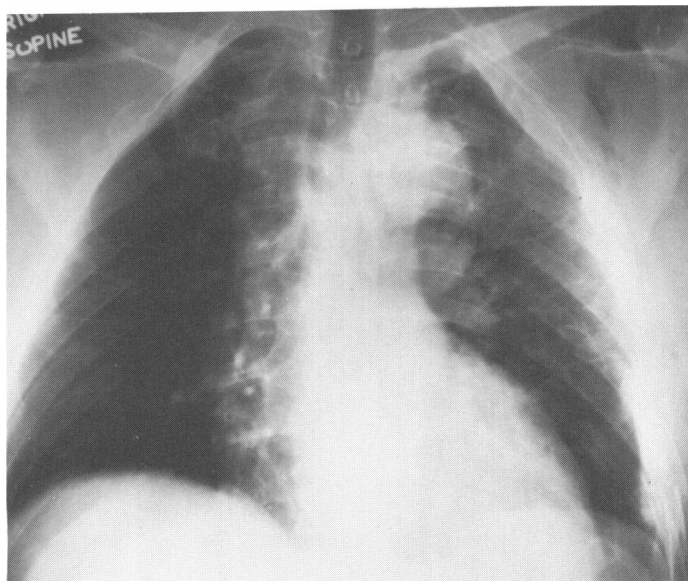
This 50-year-old man presented to the Emergency Room subsequent to blunt thoracic injury in an automobile accident. The radiograph at that time revealed a wide mediastinum, left apical pleural cap, fractures of the first five ribs on the left and of the second rib on the right, and subcutaneous air in the left axilla. All these findings indicate severe trauma with a potential for more serious injury and that thoracic aortography should be performed rapidly and expeditiously.
